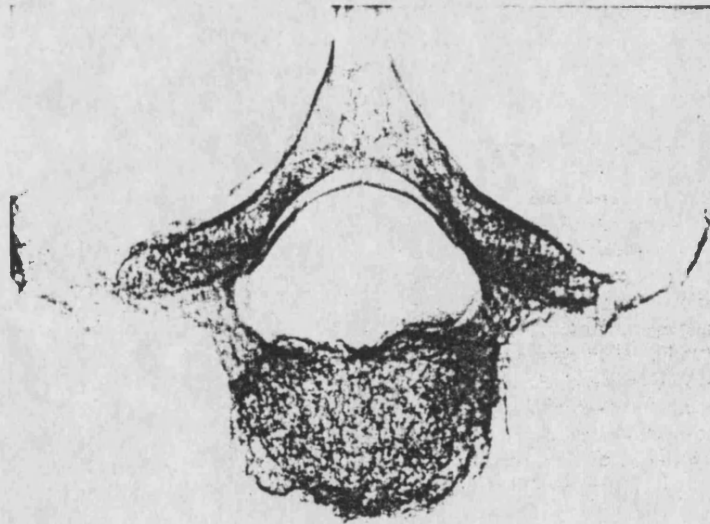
X-ray of sample 4.
